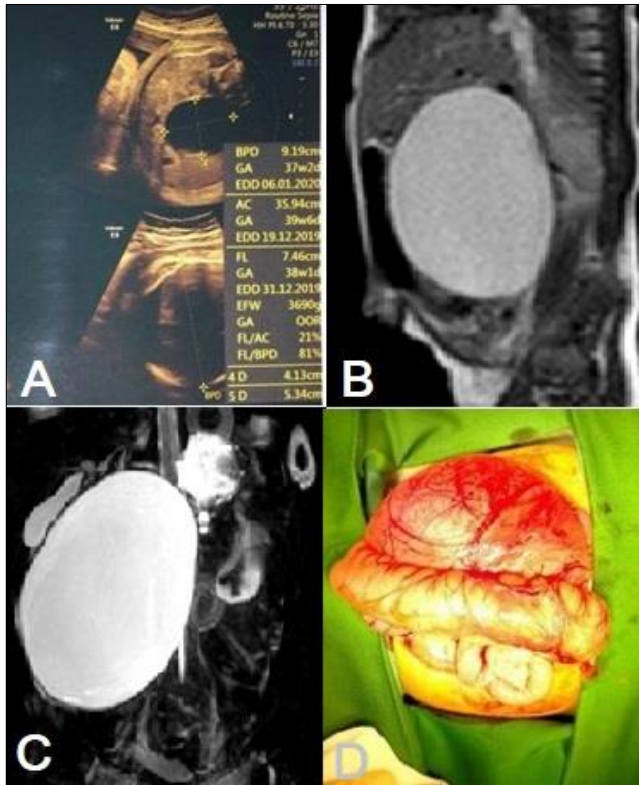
A) Antenatal scan showing a cyst, B) MRI showing a hyper-intense cyst. C) MRCP showing CC type 1. D) Operative picture showing a huge cyst
